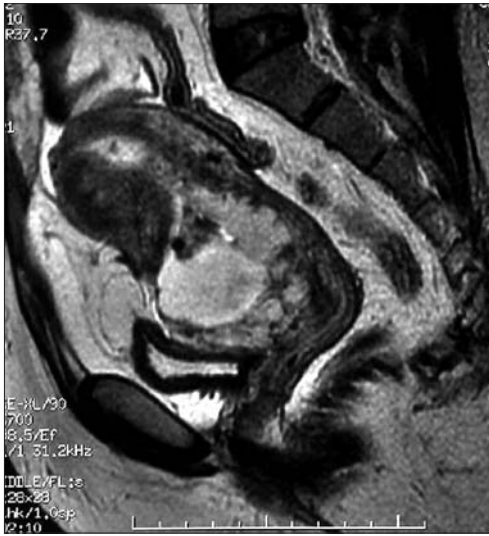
Sagittal T2-weighted MR image shows a heterogenous high-signal intensity mass that occupies the cervical anterior wall, which is very fine.
